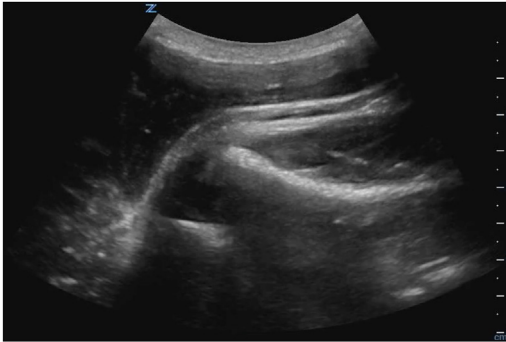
A shoulder effusion is evidenced by compressible hypochoic fluid with absence of Doppler signal within the joint space.
